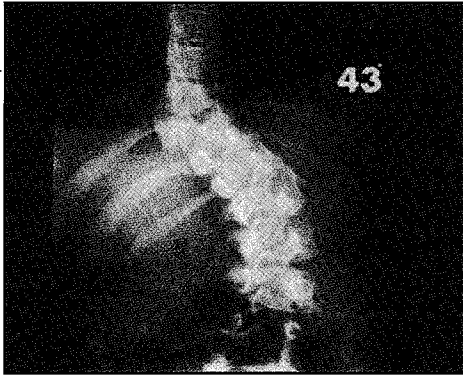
A-P radiograph of patient with Type 3 vertebral anomaly at age 4 years and 1 month. The coronal curve is 43 degrees.
